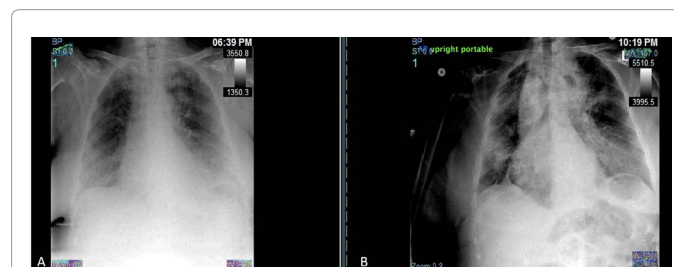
A: Follow up chest X-ray at four weeks post discontinuation of amiodarone showing significant reduction of alveolar and pleural abnormalities. Patient had full resolution of clinical symptoms. B: Baseline chest radiograph obtained upon first hospital admission for bilateral pneumonia that showed quite extensive bilateral infiltrates.
